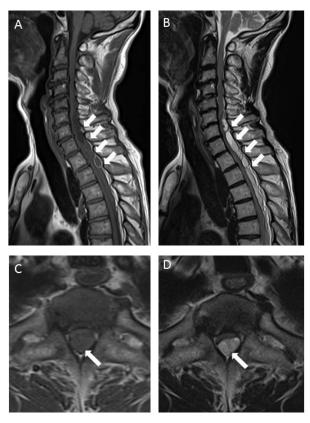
The T1- (A, C) and T2- (B, D) weighted images of the initial spinal MRI show a thick epidural hematoma compressing the spinal cord dorsolaterally. C and D are axial images of the T1 level. There are septa in the hematoma (arrows) and hematoma showed mixed intensities both in T1 and T2 images
